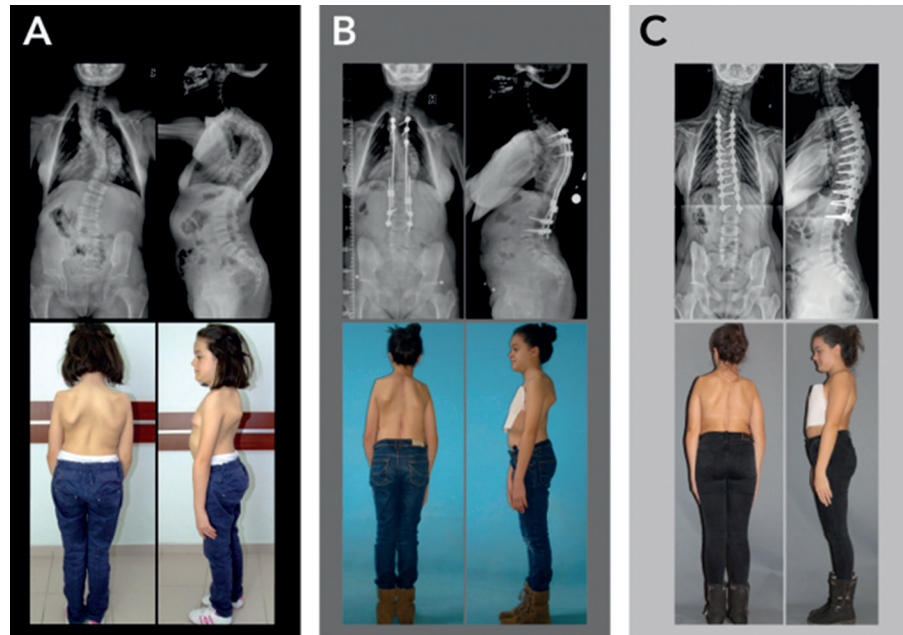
EOS with cleidocranial dysplasia (in a 12-year-old female). Treatment completed with fusion as a result of three lengthenings. The follow-up period was 33 months. (A) Preoperative AP-lateral x-rays (74° thoracolumbar scoliosis and 70° thoracic kyphosis), (B) PJK developed (25°) during GR, (C) the latest follow-up after posterior fusion with PJK regressed during the early postoperative-fusion period (9°). The major curve reduced to 19° scoliosis and 34° kyphosis.
